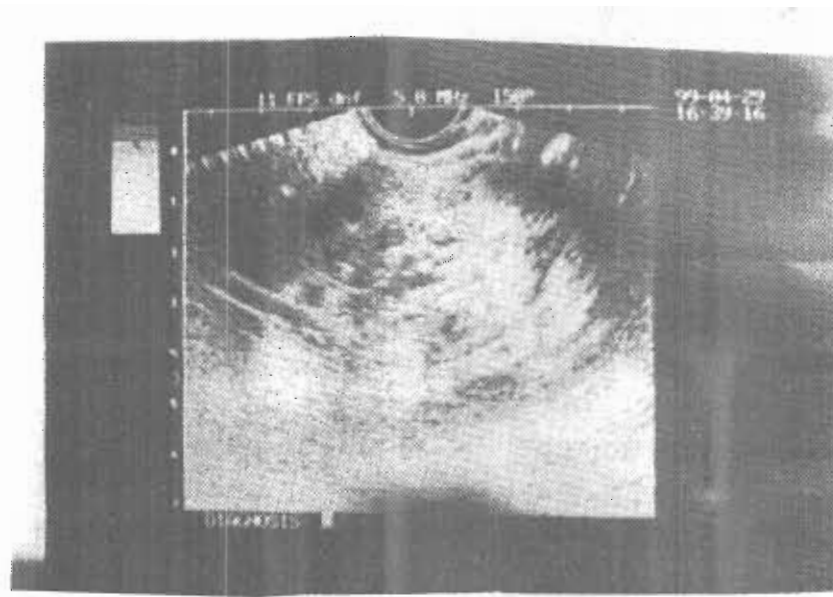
Ultrasography of the testicular seminoma revealed a diffusely heterogeneous parenchyma with hypoechoic nodules through the testicular parenchyma. No normal testicular tissue was identifiable.
